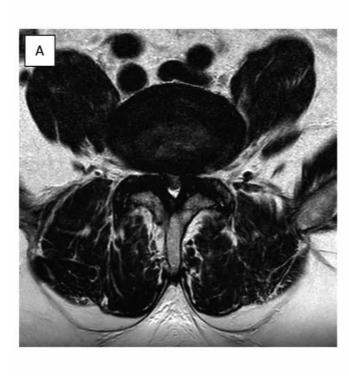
A. Axial T2 MRI demonstrating bilateral central stenosis at the L4-L5 level (February 2020). B. Sagittal T2 MRI demonstrating the well-defined lesion at the L4-L5 disc space (February 2020). MRI, magnetic resonance imaging.
